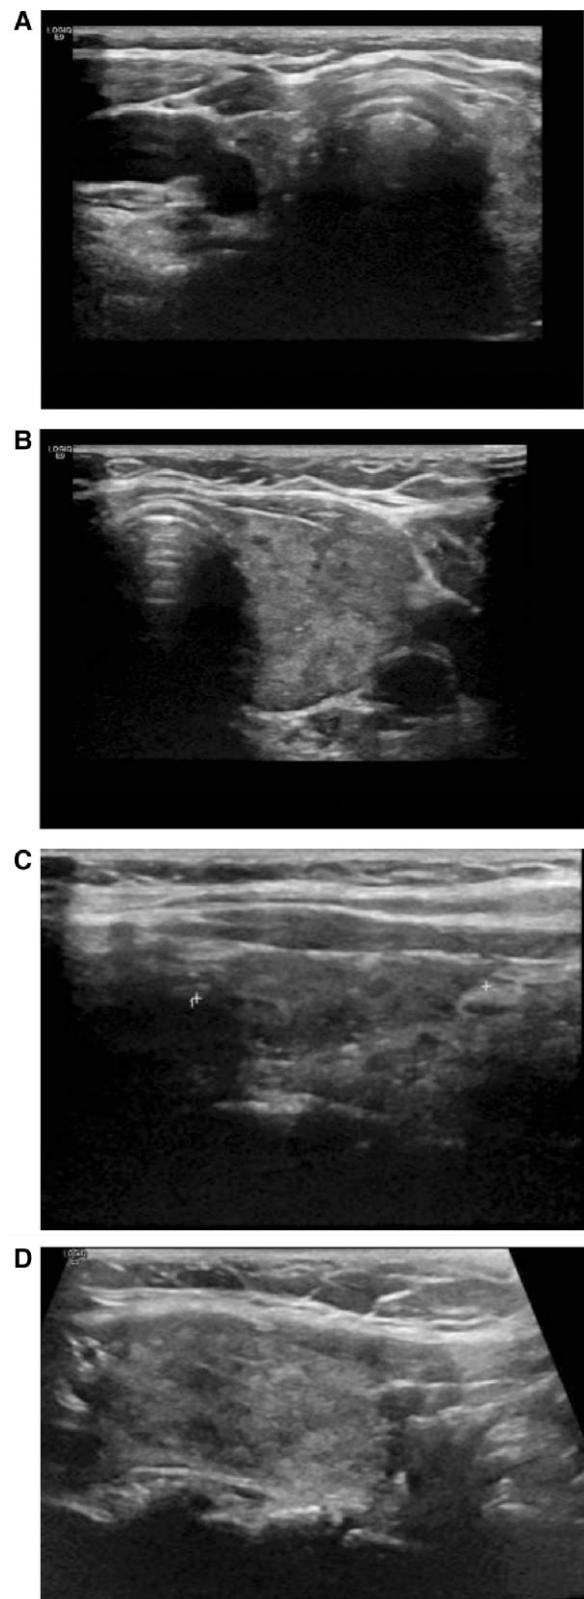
Thyroid ultrasound. (A) Transverse view and (C) sagittal view show a normal right thyroid lobe with no nodules or cysts. (B) Transverse view and (D) sagittal view show an enlarged left lobe with heterogeneous echotexture and hypervascularity, with no nodules or cysts.
